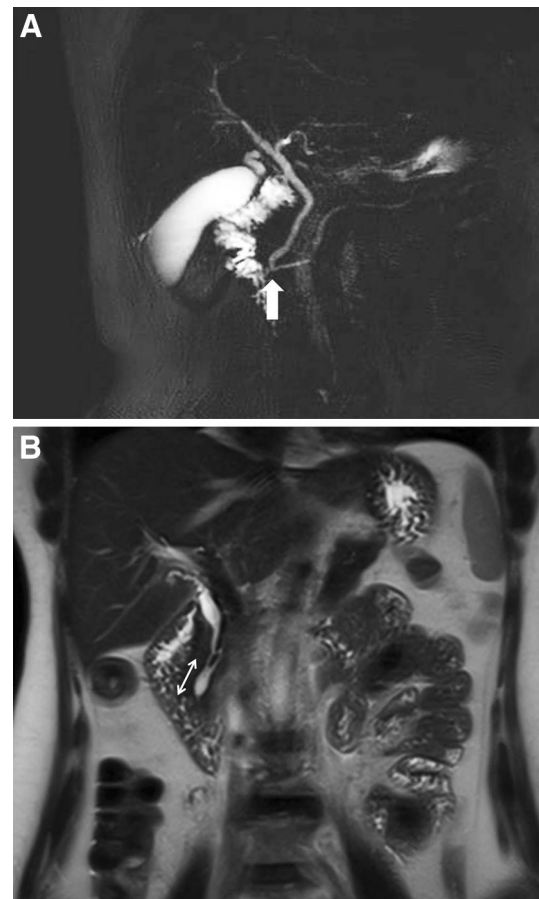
Normal and anomalous pancreaticobiliary junction. a Coronal MRCP in 60-year-old woman with bloating shows normal pancreaticobiliary junction (*arrow*). b Heavily T2-weighted MR image in 45-year-old woman with previous pancreatitis shows long common channel of pancreaticobiliary junction approximately 18 mm (*double-headed arrow*), consistent with anomalous pancreaticobiliary junction
